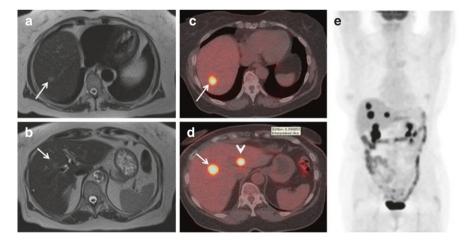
Role of PET-CT in hepatic metastases. 75-year-old with previous right hemicolectomy. Conventional contrast enhanced MRI demonstrated two hepatic metastases seen here on the axial T2W images in segment 7 (arrow in a) and segment 4a (arrow in b). Fused PET-CT images however demonstrated three intensely FDG avid lesions, two corresponding to the lesions seen on MR (arrows in c and d) but in addition picked up a lesion in segment 2 (arrow head in d). The three liver lesions are clearly seen on the MIP mage (e). FDG PET-CT has complimentary role to MRI and can pick up lesions which can be missed on MRI
